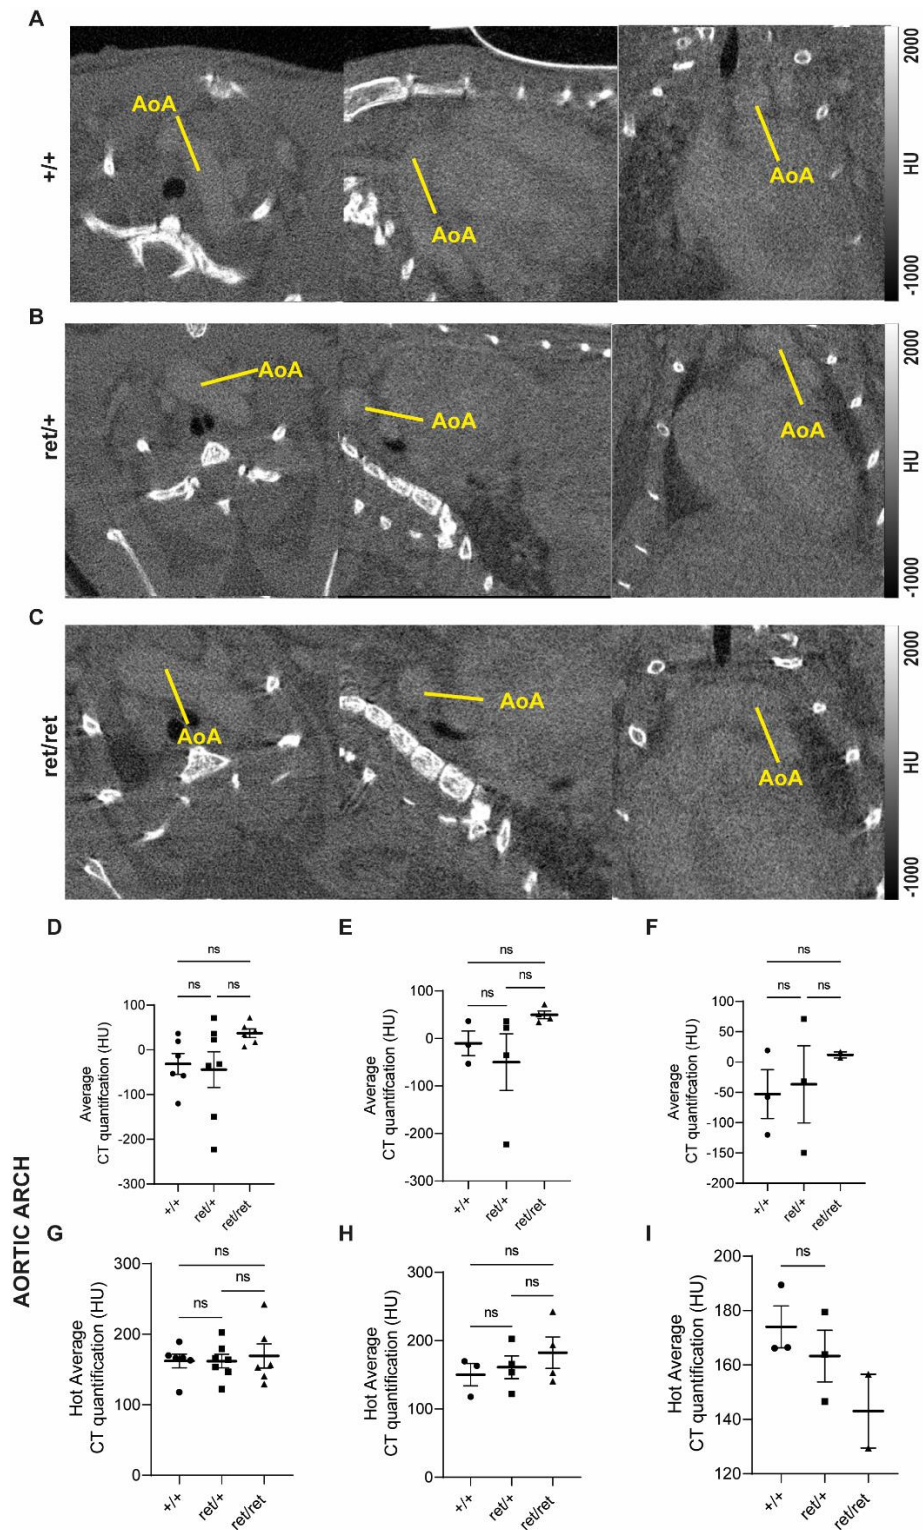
Visualisation of the aortic arch (AoA) using contrast CT and CT quantification.
